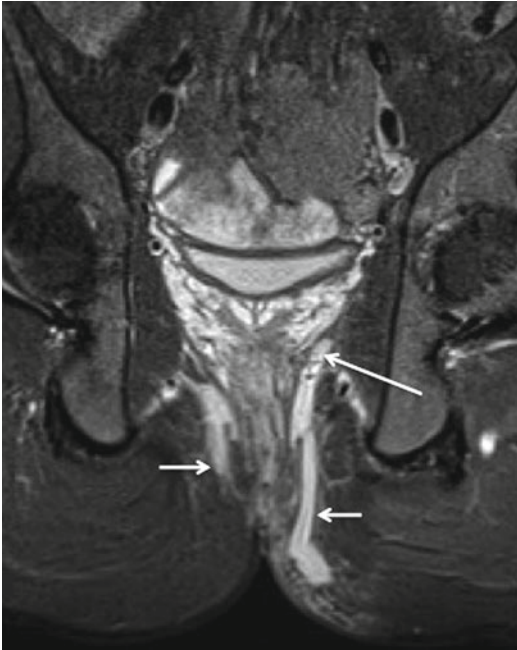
Coronal STIR MRI in a patient with bilateral transsphincteric fistulas (*short arrows*). There is an extension (*long arrow*) from the apex of the left fistula into the roof of the left ischioanal fossa
